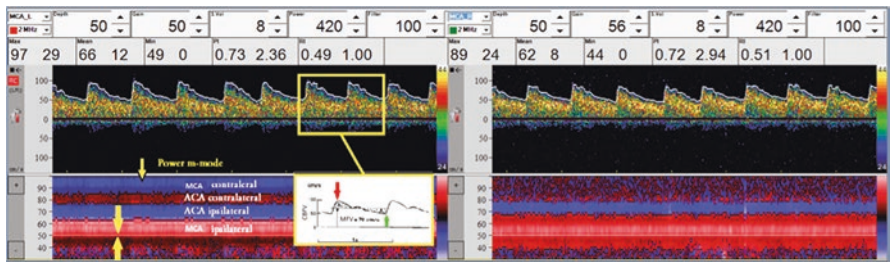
Transcranial Doppler display of BoxX® (DWL, Singen, Germany)
